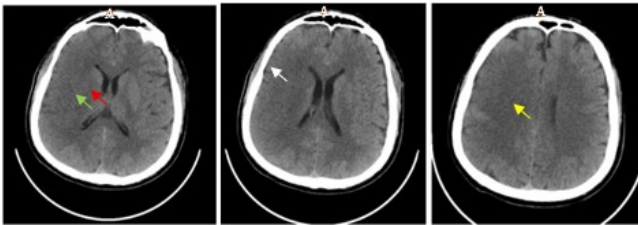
First non-contrast head CT scan, 3 hours after onset, shows sulcal narrowing (white arrow) and slight hypodensity in the right frontotemporoparietal lobe (yellow arrow), lentiform nucleus (red arrow), and insula (green arrow)
